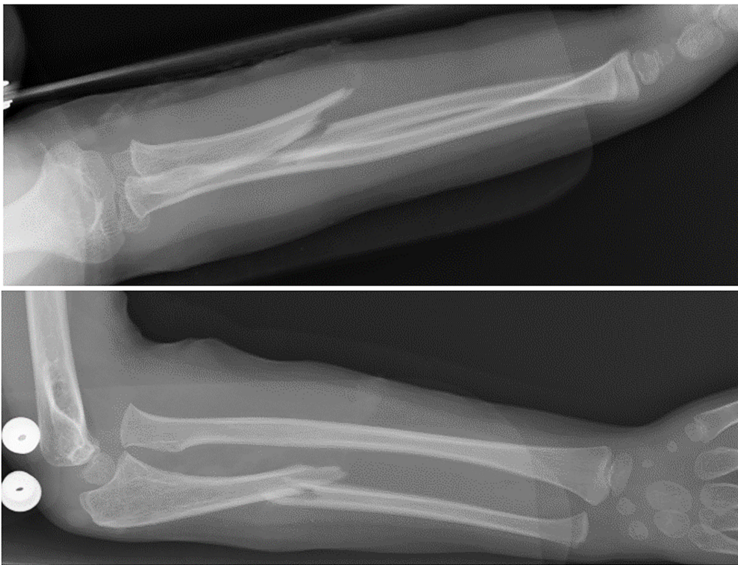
Plain X-ray taken at the time of injury revealing a fracture of the proximal third of the ulna and anterior dislocation of the radial head.
